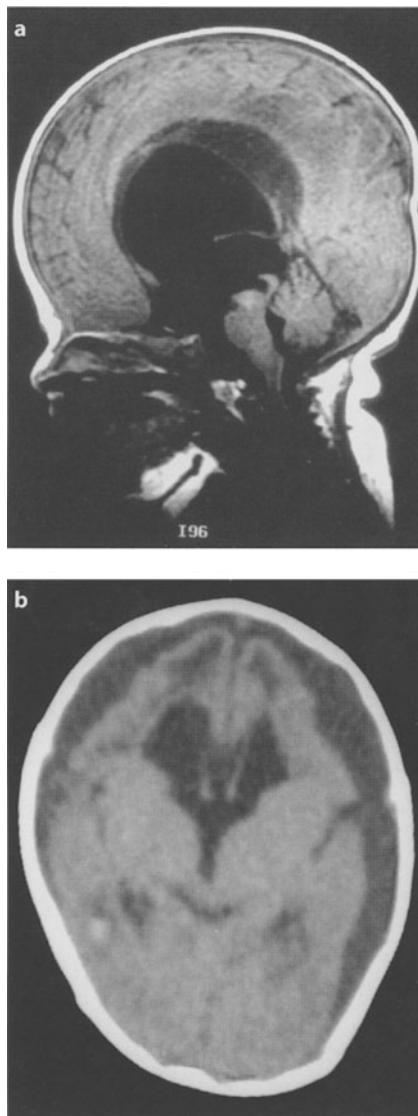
A 3-month-old premature baby with hydrocephalus. a Sagittal T1-weighted MRI shows massive ventricular dilatation. The aqueduct is obstructed at its distal end. b Same patient after shunting. The ventricles are smaller. Note the subdural effusion
